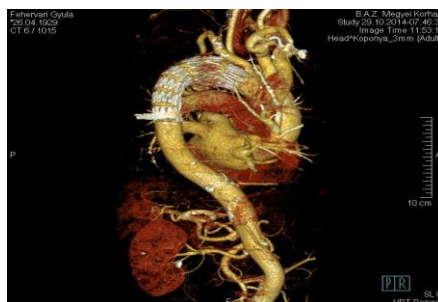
Angio CT with 3D reconstruction. The ostium of left subclavicular artery visible
